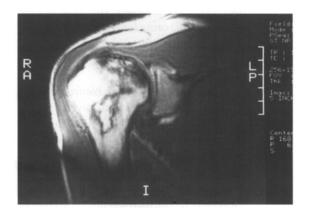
Magnetic resonance imaging of the right shoulder: on these slightly 'TI-weighted' images there is evidence of marked distortion of the marrow signal with areas of necrosis indicated by the dark signal. There is also cortical irregularity. This process involves the articular surface of the glenohumeral joint.
